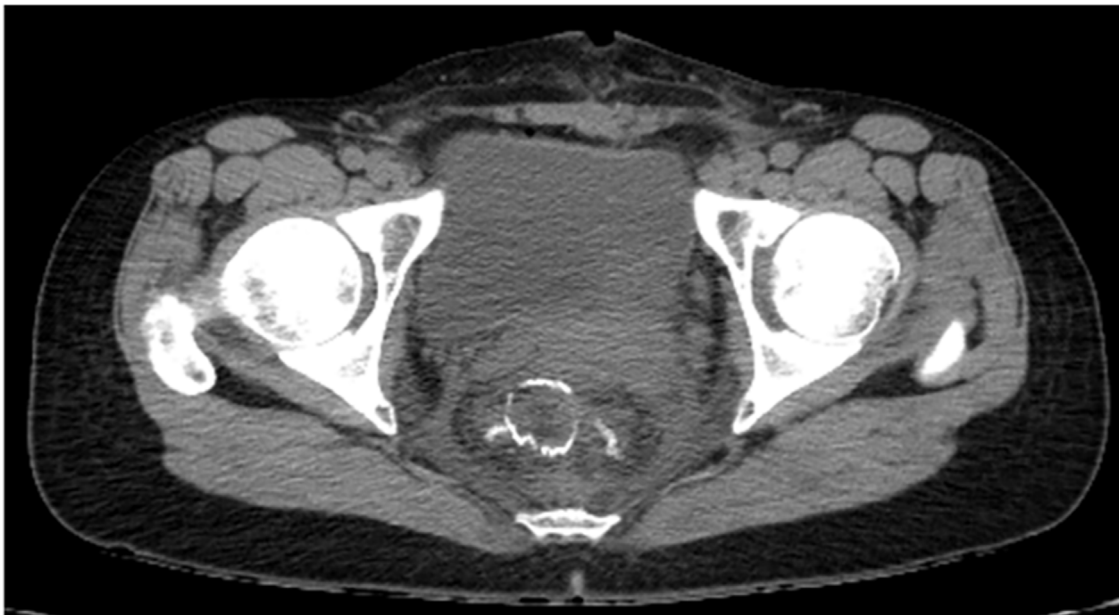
CT-scan of the abdomen 12 days after the operation.
